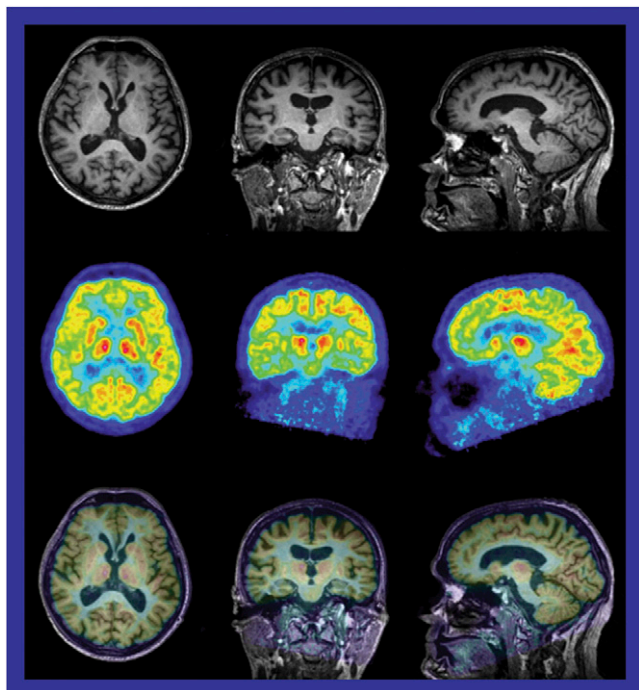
Simultaneously recorded MR/PET images. Top row, T1-weighted MR images acquired 10 min after injection of ^{18}F -FDG; middle row, PET images acquired 20–50 minutes after tracer injection; bottom row, combined MR/PET images.
